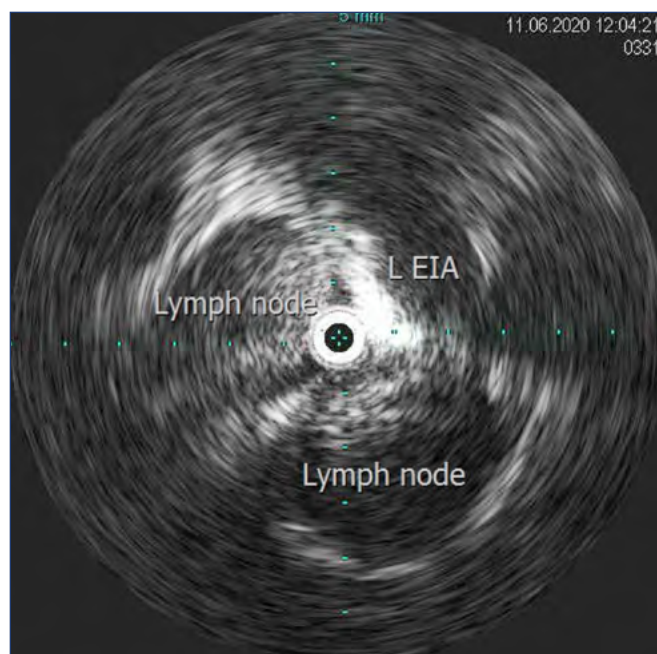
Intravascular ultrasound (IVUS) demonstrating compression of the left external iliac vein by surrounding lymph nodes.
